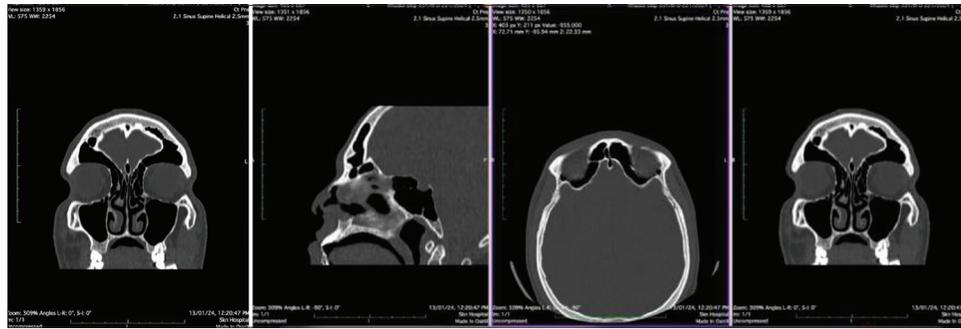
Aerated crista galli in the coronal plane on CT
